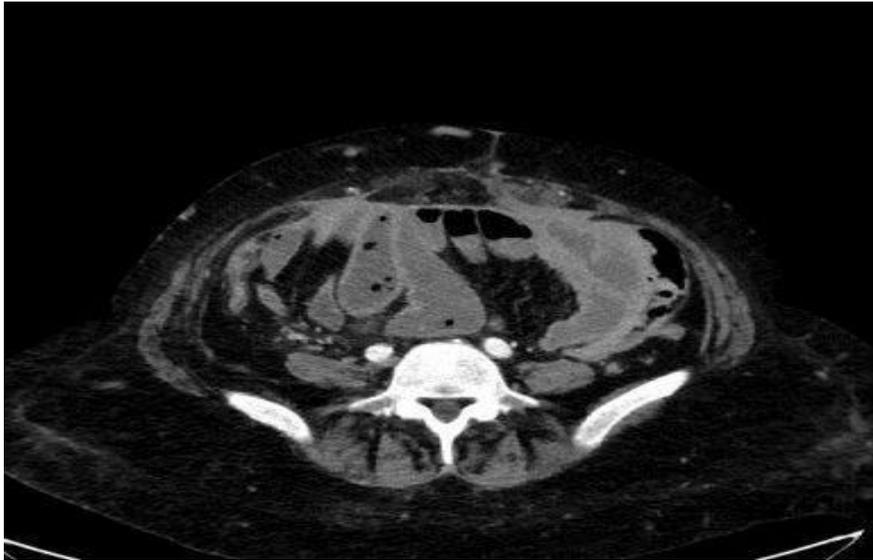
The abdominal CT scan showing the same findings of figure 3.
